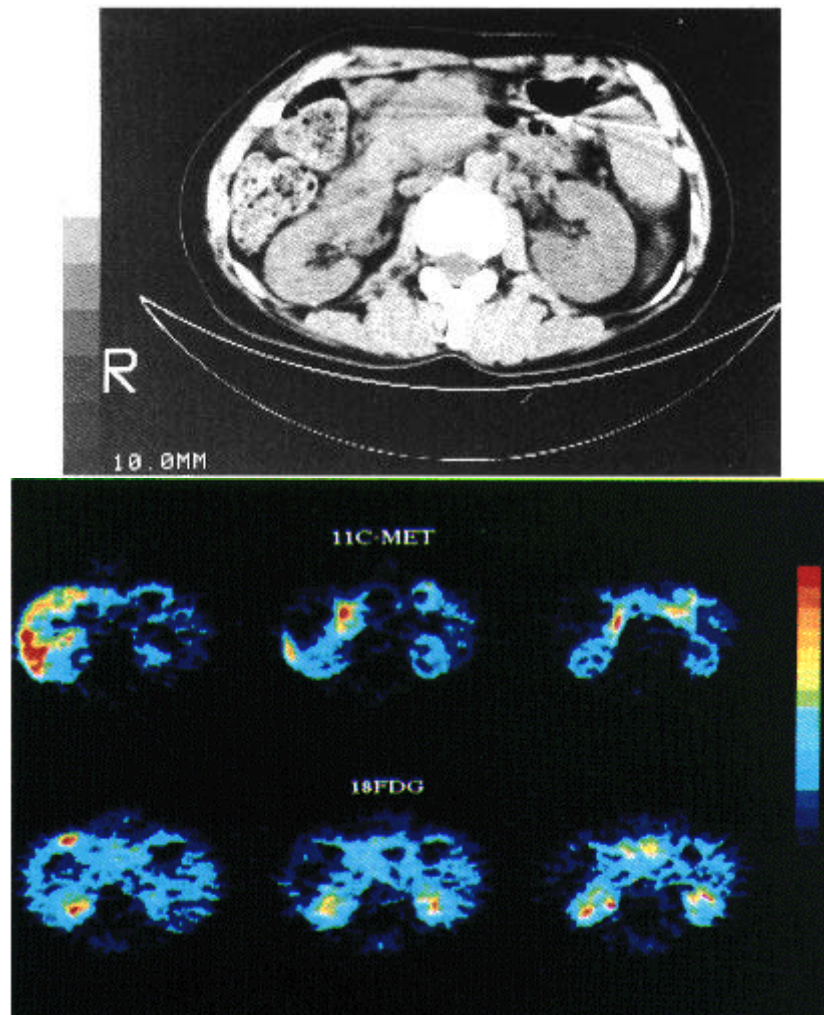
A 47-year-old female with pancreatic body cancer (Case 24 in Table 1). (A) X-CT: The tumor of the pancreatic body can be recognized. (B) PET: PET image of the left is more cranial than the right. Upper line is PET images using ^{11}C -Met. The head and tail of the pancreas can be clearly shown, but the body occupied by tumor can not be visualized as hot image. Lower line is PET images using ^{18}F FDG. The tumor of the pancreas can be recognized.
